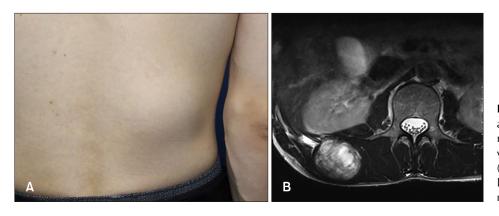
(A) A 75-mm×70-mm, movable, subcutaneous nodule on the right side of the lower back (clinical view of a 37-year-old Japanese male). (B) A high-density area in the right latissimus dorsi muscle (T2-weighted magnetic resonance imaging).
